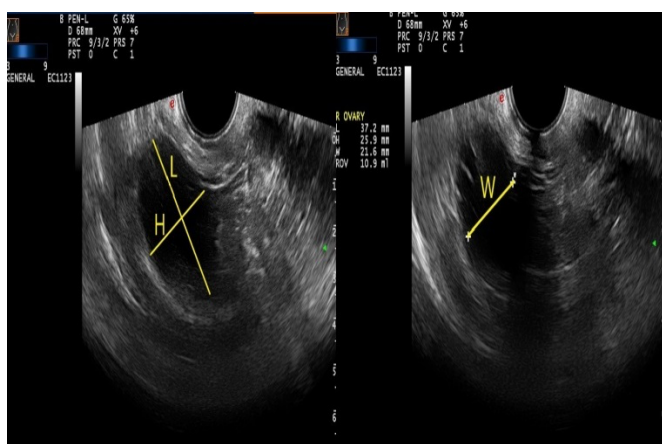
Calculation of ovarian volume ultrasonographically
